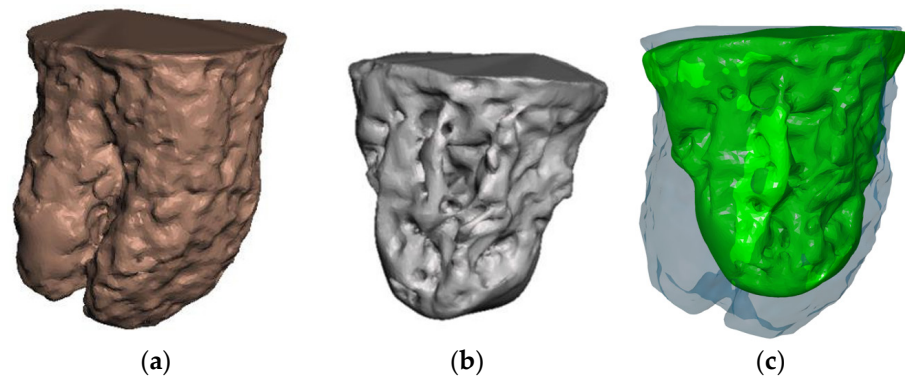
Surface 3D models of reconstructed cavities (a) after the first CBCT imaging and (b) after the second CBCT imaging and (c) overlap of surface 3D models of the first (bluish transparent color) and second CBCT measurement (green color) of the same patient.
